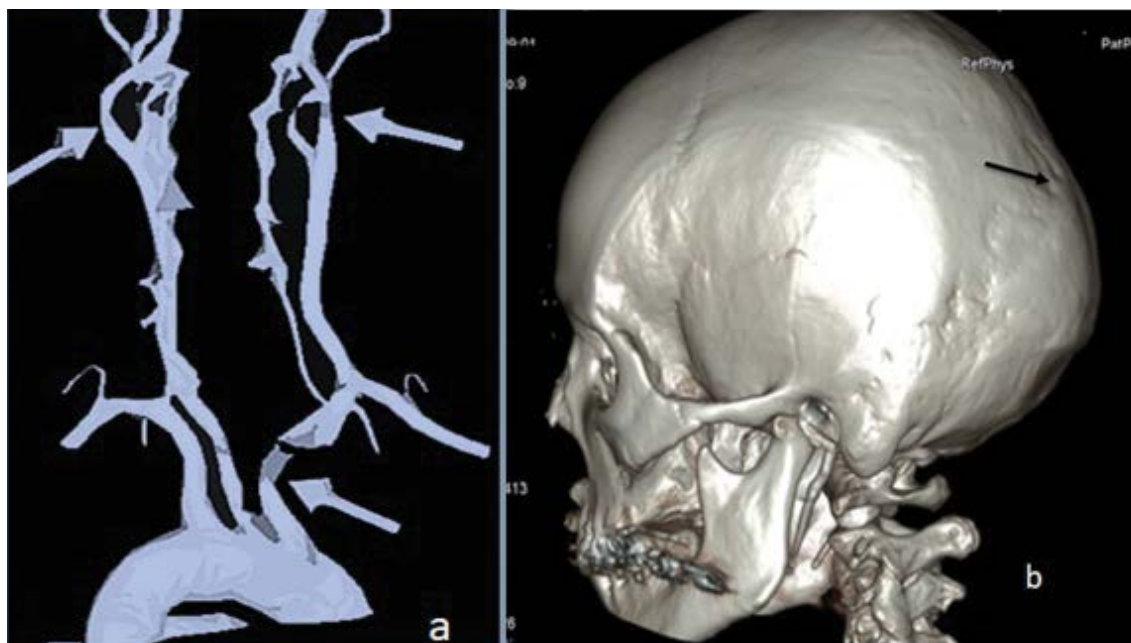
a,b. 3 D contrast- enhanced computed tomography angiography of the cerebral arteries showed kinking and tortuosity along several segments of the right and left common carotid arteries. Maximal magnitude of stenosis and kinking along the lower third of the left common carotid artery and kinking of the left subclavian artery (arrows). Stenosis is apparent along the right and left internal carotid arteries. Similarly degenerative pathology involving the vertebra-basilar arteries of maximal intensity over the left part (arrow) (a). 3D reconstruction CT scan of the cranial bones showed Wormian bones (arrow) along the lambdoid sutures associated with bulging of the occiput (b). Wormian bones are irregularly shaped bones formed from independent ossification centres found along cranial sutures (mainly along the lambdoid sutures), note the bulging occiput. Wormian bones can be encountered in (76) syndromic entities (London Medical Database).
